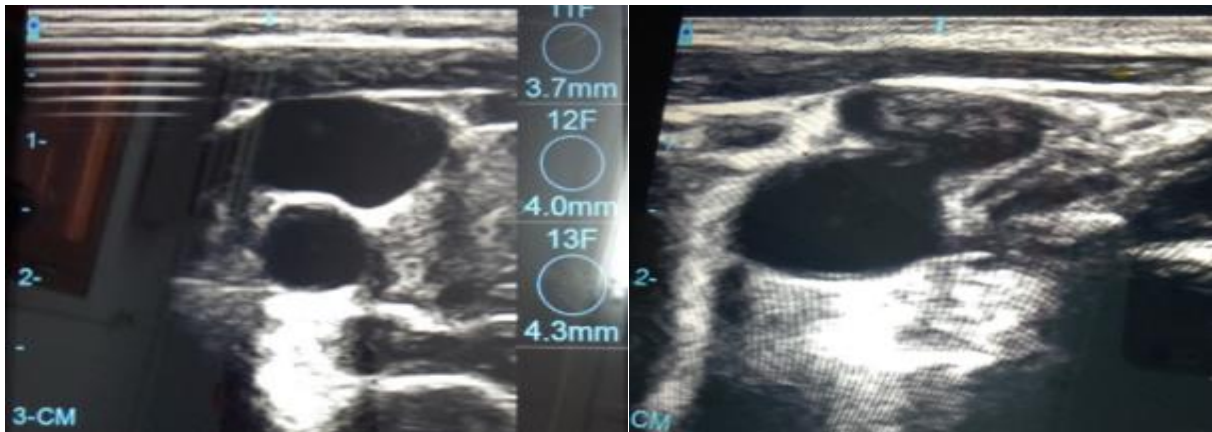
Ultrasound appearance of vascular variations and thromboses.
